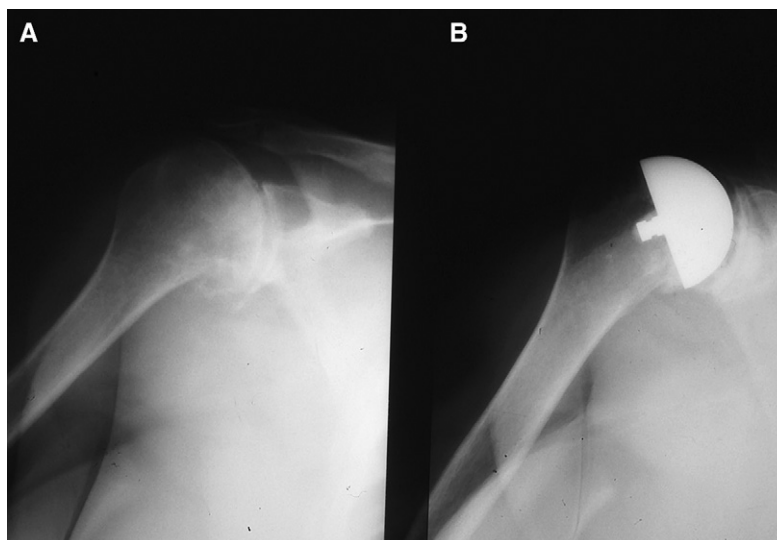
Anteroposterior shoulder radiographs. A, Preoperative image with advanced glenohumeral arthritis. B, Postoperative image taken after insertion of total resurfacing prosthesis.
